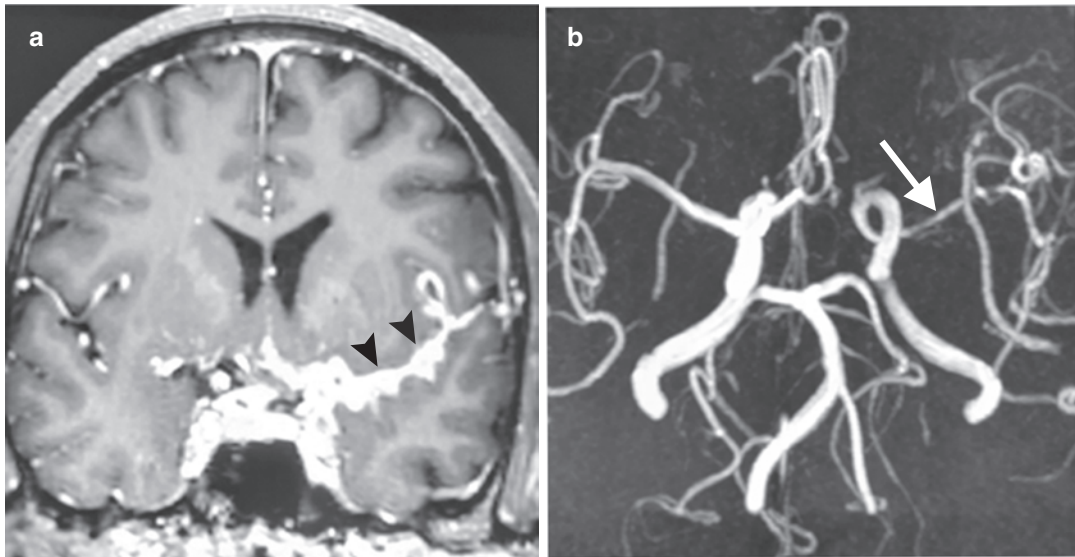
Middle cerebral artery vasculitis. (a) Coronal contrast-enhanced T1-W and (b) 3D time-of-flight MR images show nodular meningeal thickening along the left
